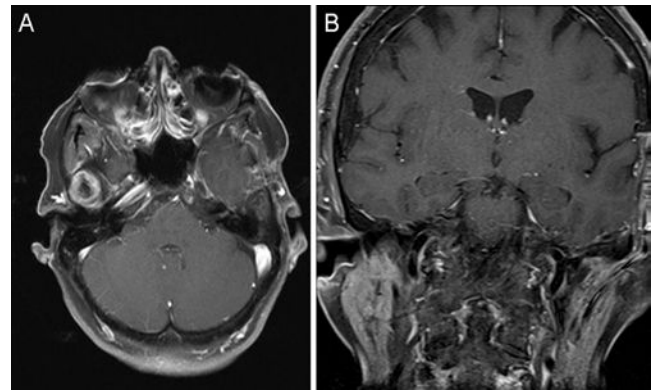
Axial (A) and coronal (B) T1-weighted MR images obtained after complete removal of the lesion. No enhancing residual lesion is evident in the left middle fossa. Fat graft is visible on the lateral floor of the left middle fossa.
